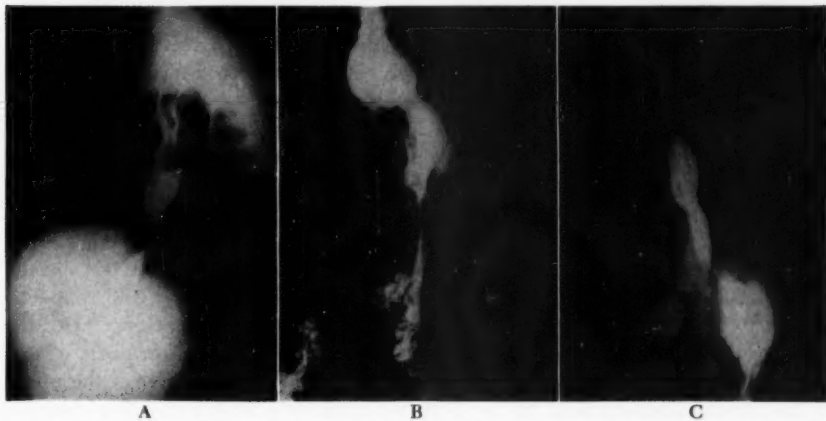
X-ray films of Mrs. E. K. before and after gastric resection for "idiopathic" (acid-peptic) esophageal stricture.
